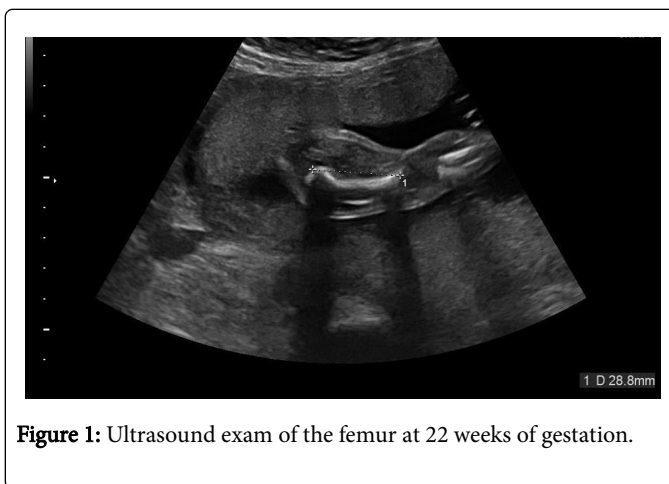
Ultrasound exam of the femur at 22 weeks of gestation.
